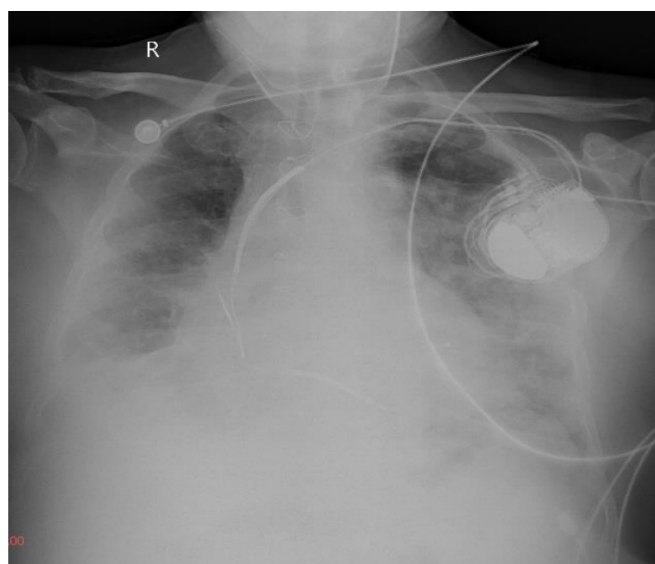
Chest x-ray of the patient at ICU
